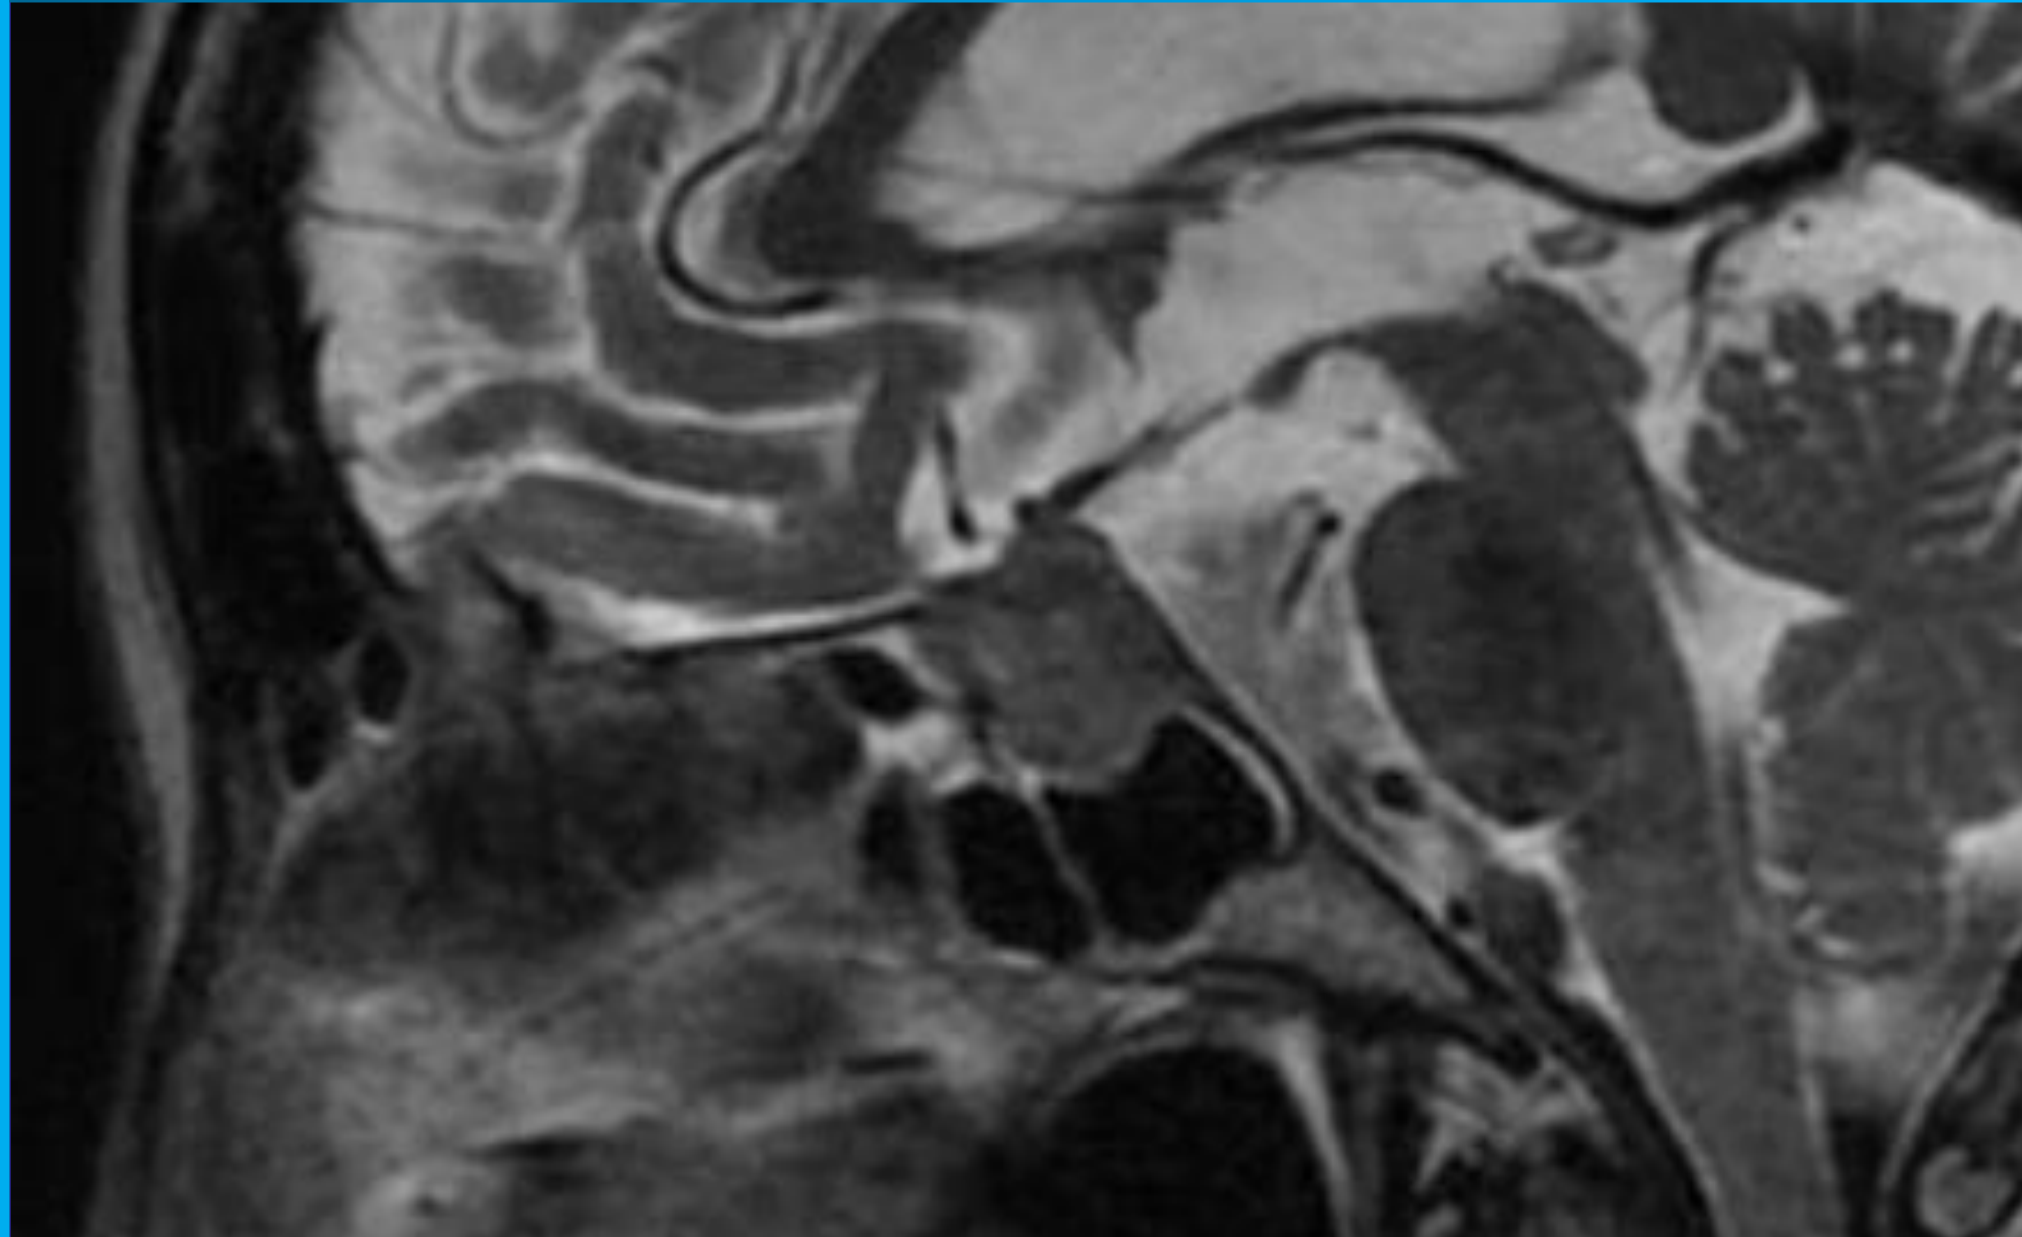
Immediate pre-operative MRI with contrast shows a 2.7x2.1x2.0 cm enhancing sellar and suprasellar mass with internal cystic components. There is upward impingement on the optic chiasm, worse on the right, and the right cavernous carotid was encased by the lesion and slightly narrowed. The mass also abutted the medial aspect of the left cavernous carotid artery. The Circle of Willis was complete.
